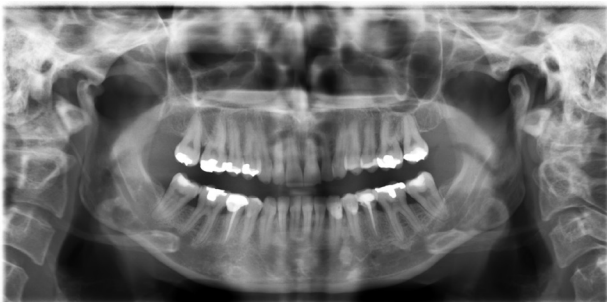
Panoramic radiographic imaging of TMJ demonstrated very well the osseous structures of TMJ and dentomaxillary region. Note that "bird beak" appearance in the right condyle which was indicative of an osteophyte and/or osteoarthritic change is seen.
